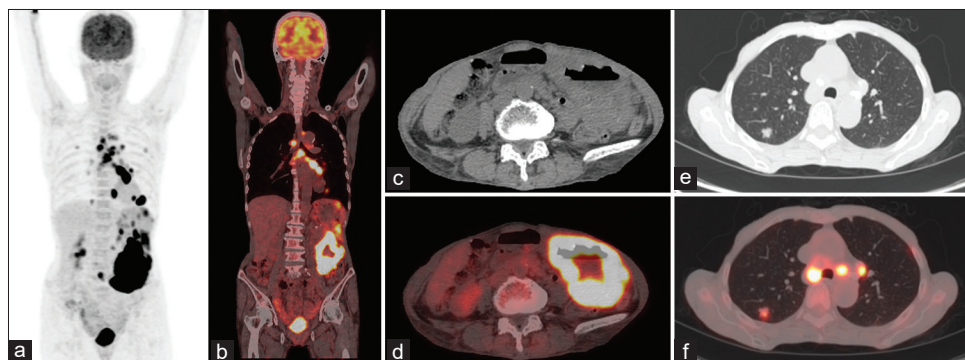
Case of 72-year-old female who was diagnosed as having adenocarcinoma of the stomach. Due to extensive nature of the primary disease, she underwent 18F-FDG Positron emission tomography/computed tomography for metastatic work-up (MIP [a], coronal positron emission tomography/computed tomography [b], Axial computed tomography [c and e], Axial positron emission tomography/computed tomography [d and f]). Apart from the bulky primary disease involving distal stomach and pylorus (b-d), extensive intensely FDG avid lymph-nodal (a, b, f) and pulmonary metastases were also found (e and f). Note must be made that this was “intestinal-type” variant, which explains the intense FDG avidity of the primary as well as metastatic disease
